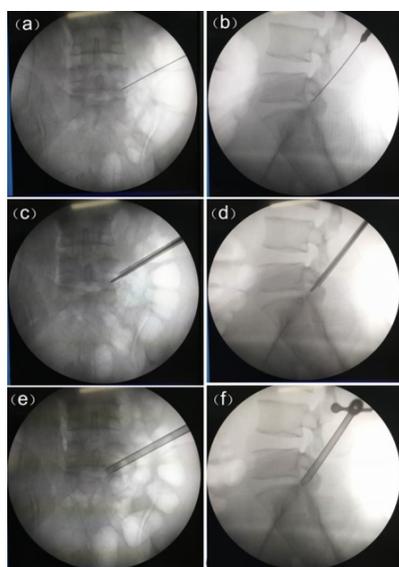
The expansion step by step. (a) and (b): The anteroposterior and lateral X-ray images of puncture needle. (c) and (d): The anteroposterior and lateral X-ray images of expansion tubes. (e) and (f): The anteroposterior and lateral X-ray images of working cannula.
